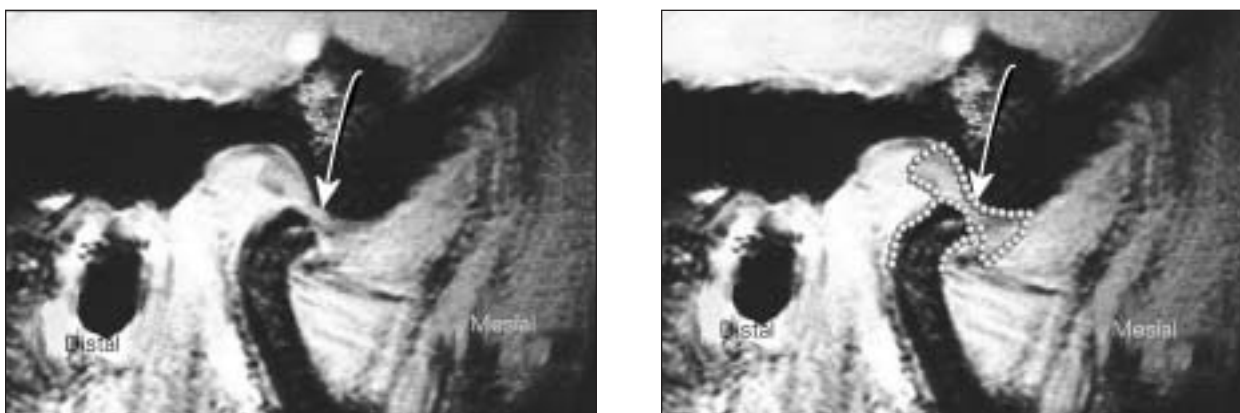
MRI of pretreatment disc reduction in the open-mouth position. The arrow points to the disc, which is interposed between the articular eminence and the condylar head. In the open-mouth position, the posterior band of the symptomatic disc assumes a seemingly normal location above the condylar head. In the figure on the right, the mandibular condyle and the articular disc are traced.
